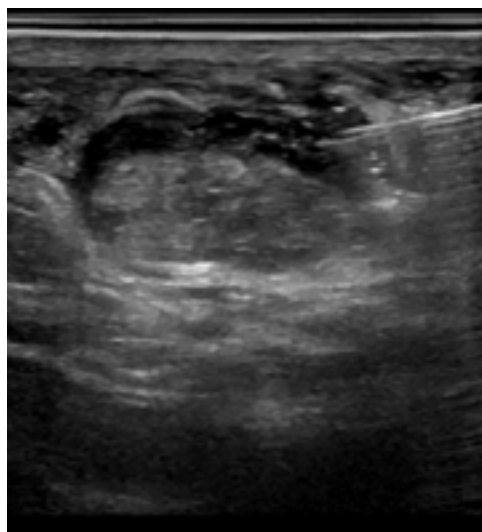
Ultrasound-guided fine needle biopsy*
